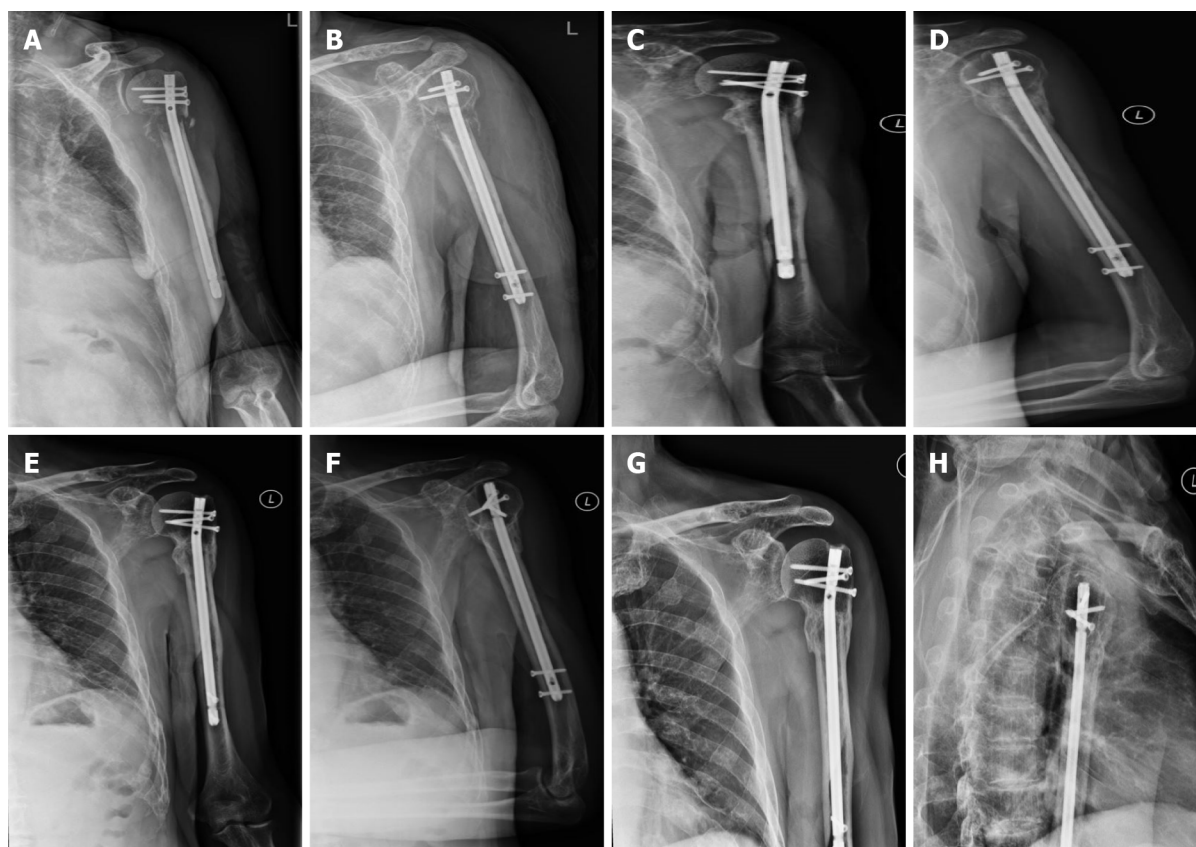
Postoperative X-ray films. A, B: Postoperative X-ray films of the left shoulder; C-H: Follow-up at 6 mo (C, D), 15 mo (E, F) and 40 mo (G, H) after surgery. The proximal humerus fracture eventually healed.
